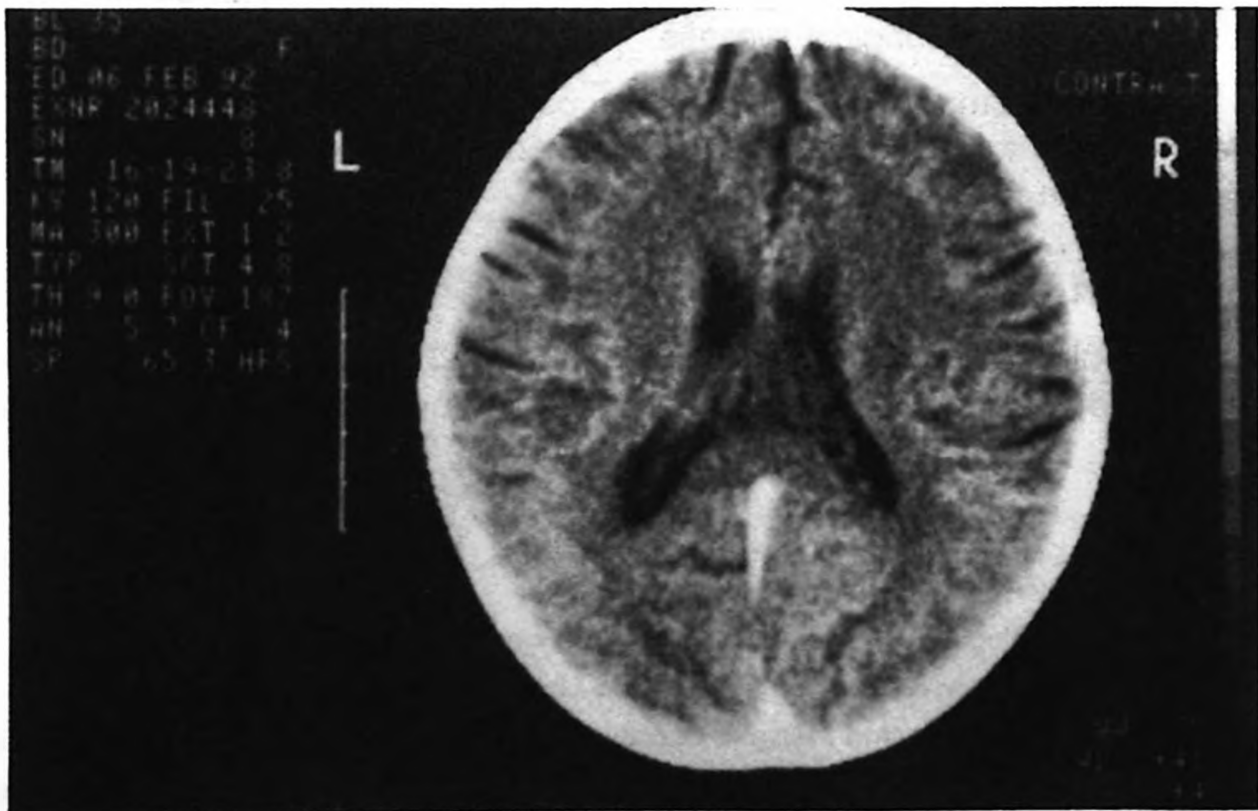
CT scan. The white matter density is normal in both of the occipital lobes.
